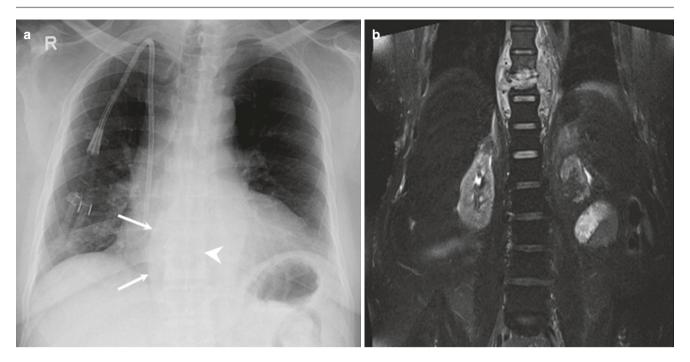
62-year-old woman with spondylodiscitis. (a) Frontal radiograph shows paravertebral opacity in the lower dorsal region with a displacement of the right paraspinal line (arrows) and narrowing of the T10–11
